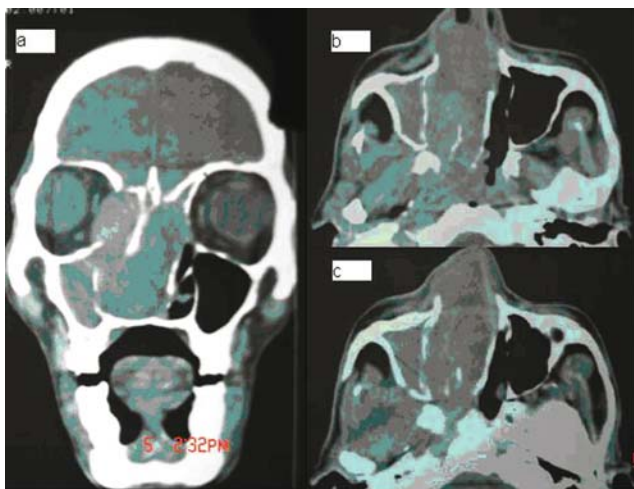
CT Scan of the patient showing tumor mass occupying the right nasal cavity eroding the medial orbital wall, the lateral nasal wall and the nasal septum (b and c). Axial CT scan of the patient showing the tumor mass occupying the whole of the right nasal cavity extending into the nasopharynx
